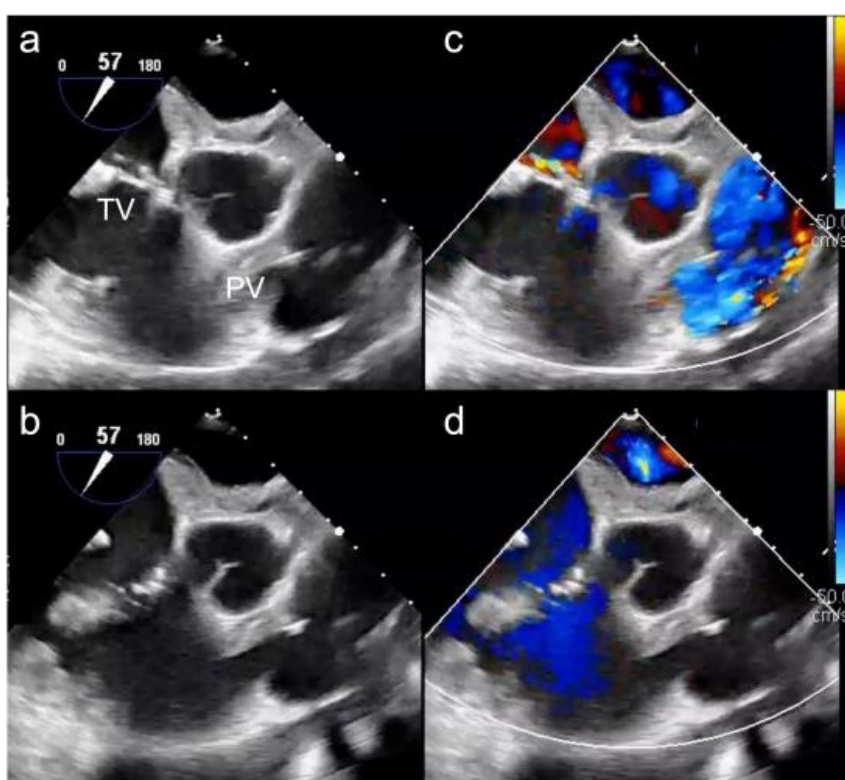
Postoperative transesophageal echocardiography of the tricuspid valve and pulmonary valve.
